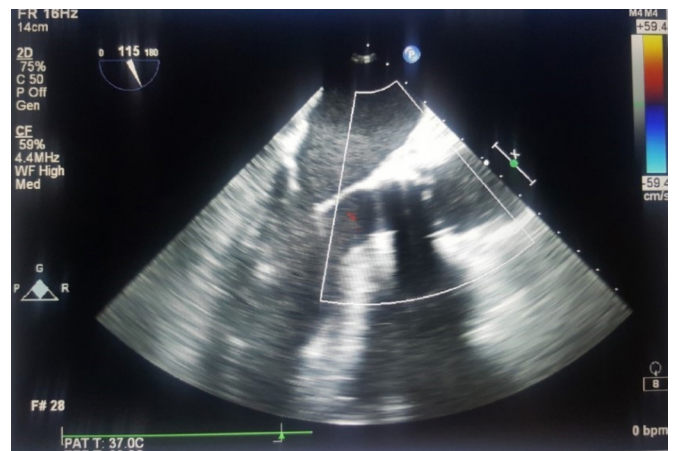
Postoperative echocardiogram valve in valve, showing no aortic regurgitation or paravalvular leak
